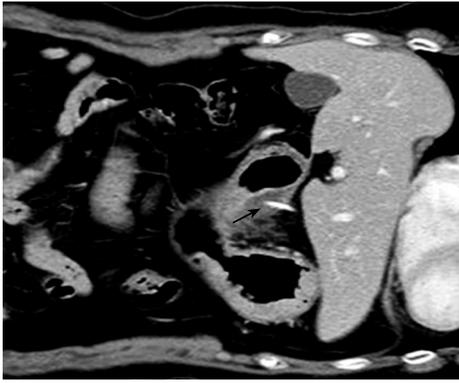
2.8 cm linear density (arrow) penetrating into the thickened gastric wall (CT).
